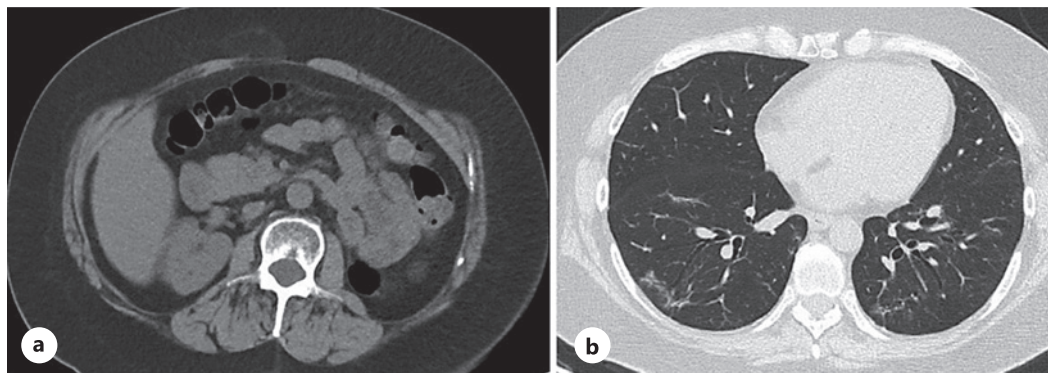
CT scan images from the patient's latest re-evaluation. a Abdominal CT scan showing no evidence of locoregional recurrence, bone lesions, retroperitoneal adenopathy, or free fluid. b Chest CT scan showing stable pseudonodular lesions in both lungs, with no cavitated lesions, indicative of sequelae. Ganglia in the aortopulmonary window and in the pretracheal retrocaval space show a stationary course, indicative of sequelae. CT, computed tomography.
